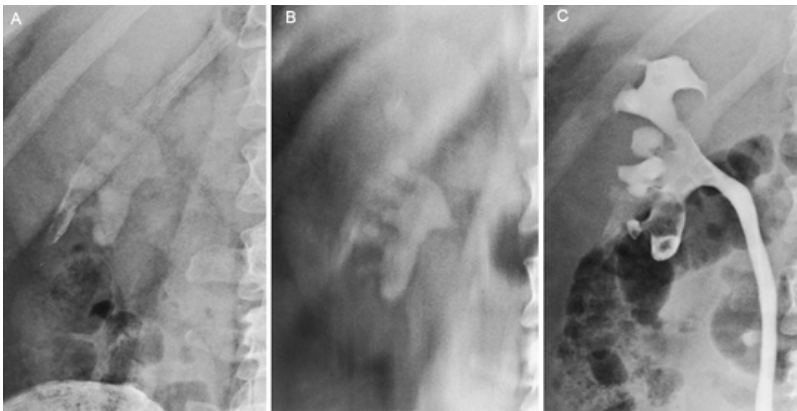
A: Plain abdominal radiograph that demonstrates a large branched right renal calculus. B: Plain tomographic film. C: Retrograde pyelogram that demonstrates a filling defect. Analysis of the removed stone material revealed 98% uric acid.
